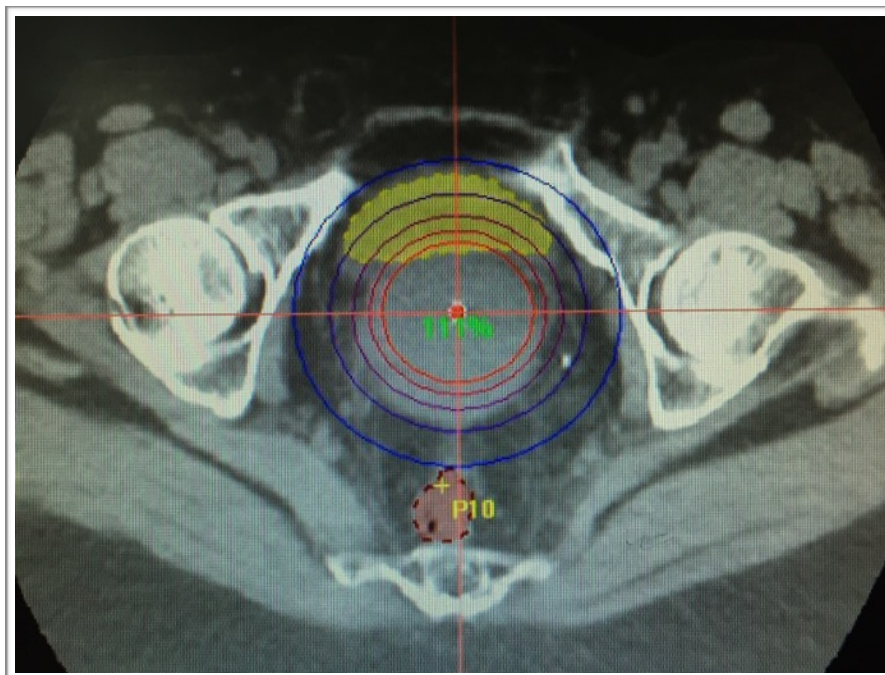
Transverse CT image showing the central applicator and bladder and rectum contoured in yellow and brown respectively. The circular dose distribution can be seen expanding outward from the source. The bladder would receive much higher dose due to the close proximity to the applicator.
